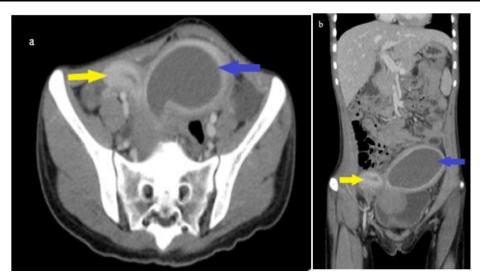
Abdomino-pelvic CT scan image with contrast media in axial section (a) and coronal section (b), showing uterus didelphys with normal uterus on the right (yellow arrow) and with hemi-hematometra on the left (blue arrow).
